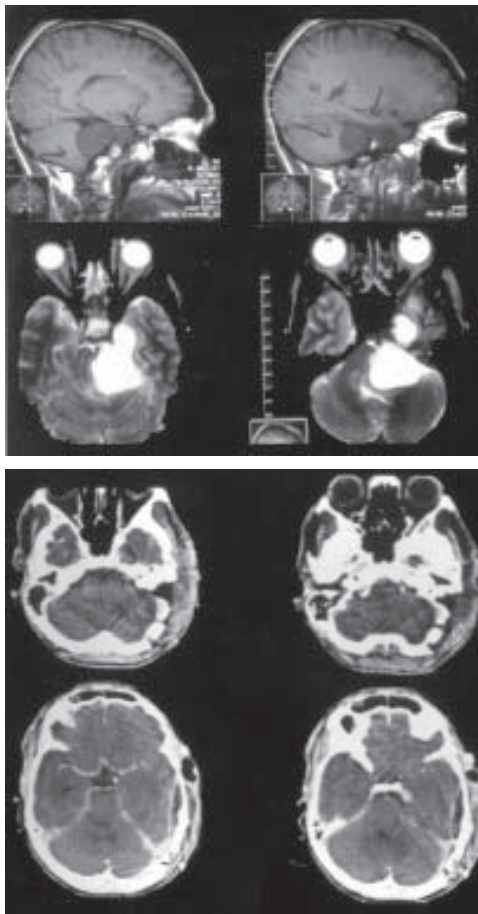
(Case 3/Type 3) – Upper – MR images showing the lesion within two compartments: middle and posterior fossa. Lower – postoperative CT-scan showing total tumor removal through a petrosal approach.
